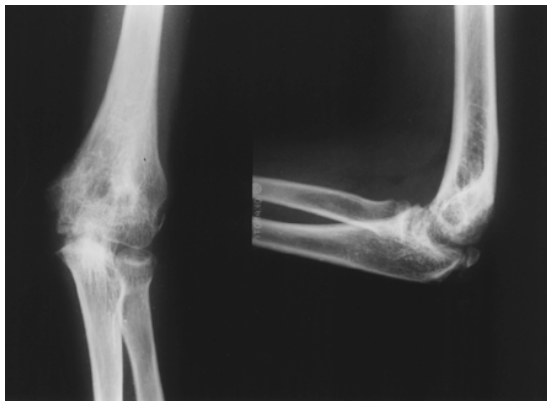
15 months F/U. AP. and Lat. X-ray. The Result by Flynn's criteria is good.
